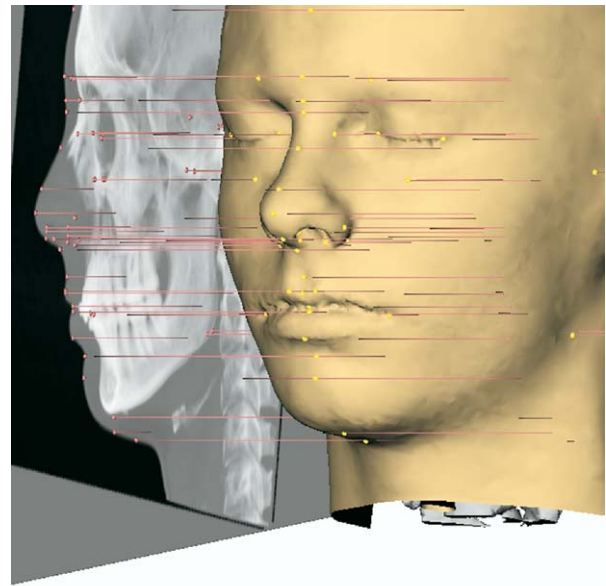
Virtual lateral cephalogram linked to 3D soft-tissue surface representation with setup of 3D cephalometric soft-tissue landmarks (MS-CT).
